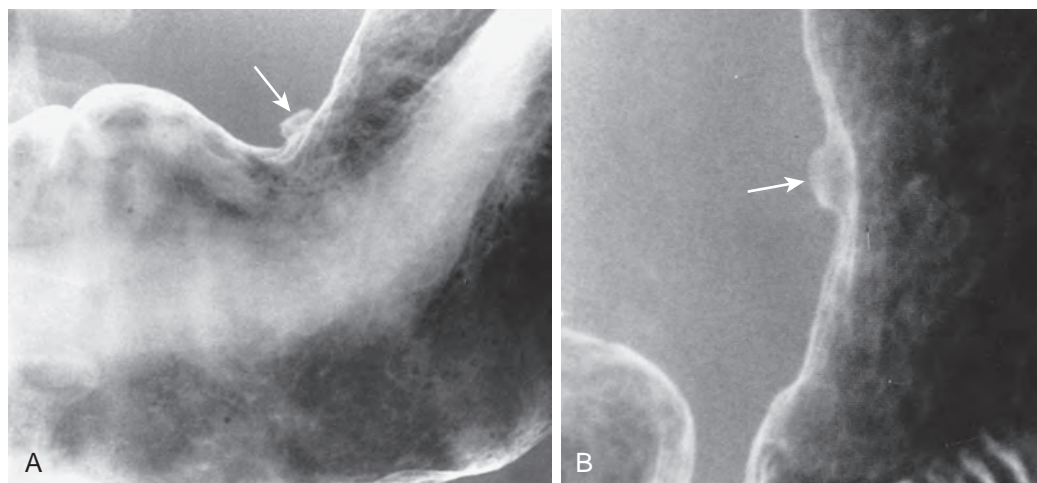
Small gastric ulcers. A, B. Despite their small size, these lesser curvature ulcers (arrows) are well seen on double-contrast radiographs.
